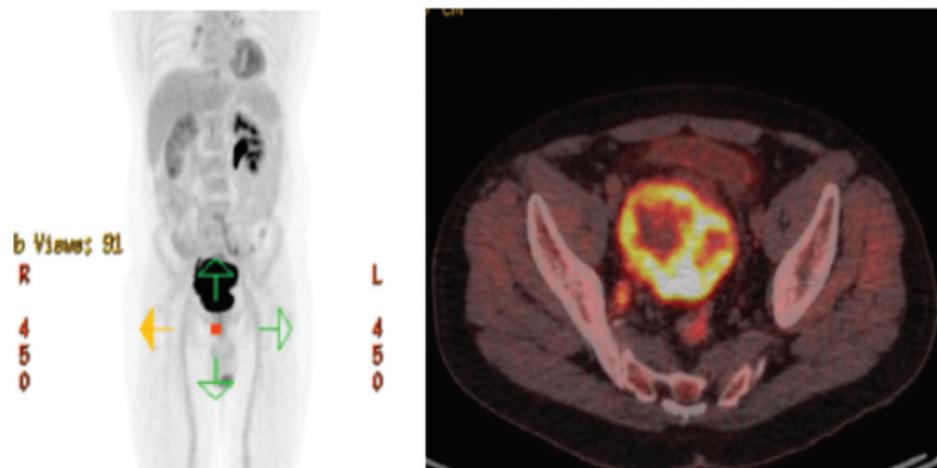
Positron emission tomography-CT, July 2020.
